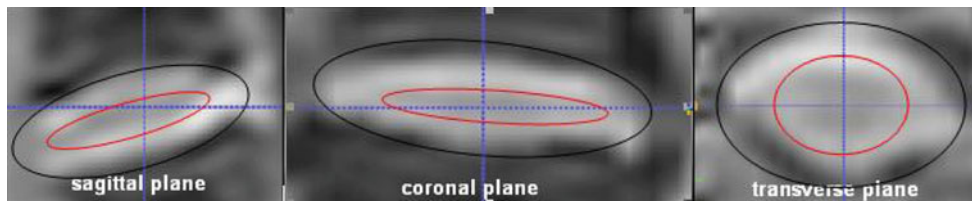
Annulus–nucleus structures of an inter-vertebral disk in MR image. The inter-vertebral disk is labeled with a *black circle*. The annulus–nucleus is labeled with a *red circle*
